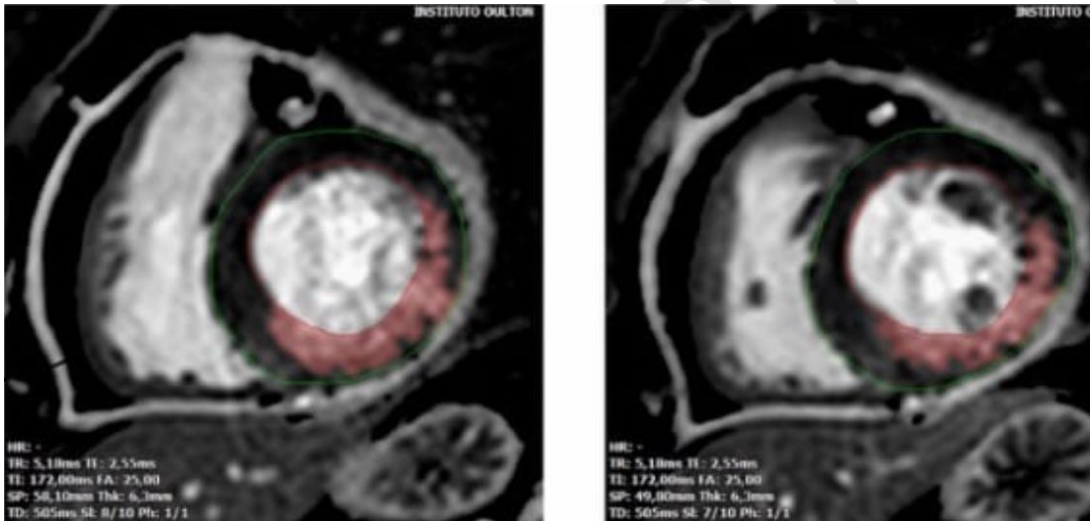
MRI demonstrated an inferior akinesia and medial and basal inferolateral akinesia with LV ejection fraction 41%)
